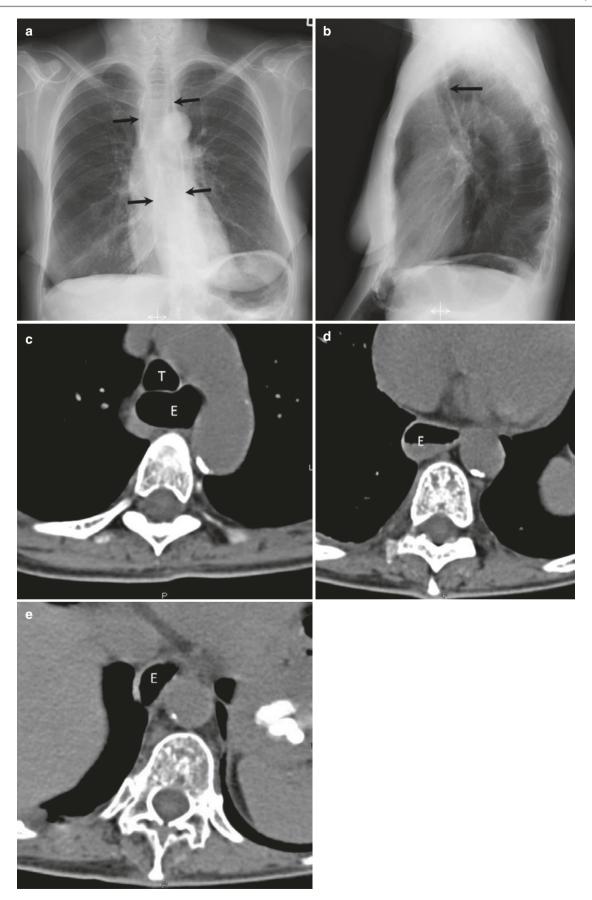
Split esophagus in achalasia. (a) A tubular structure in the posterior mediastinum with displacement of azygo-esophageal line representing dilated esophagus (arrows). (b) Lateral radiograph shows
